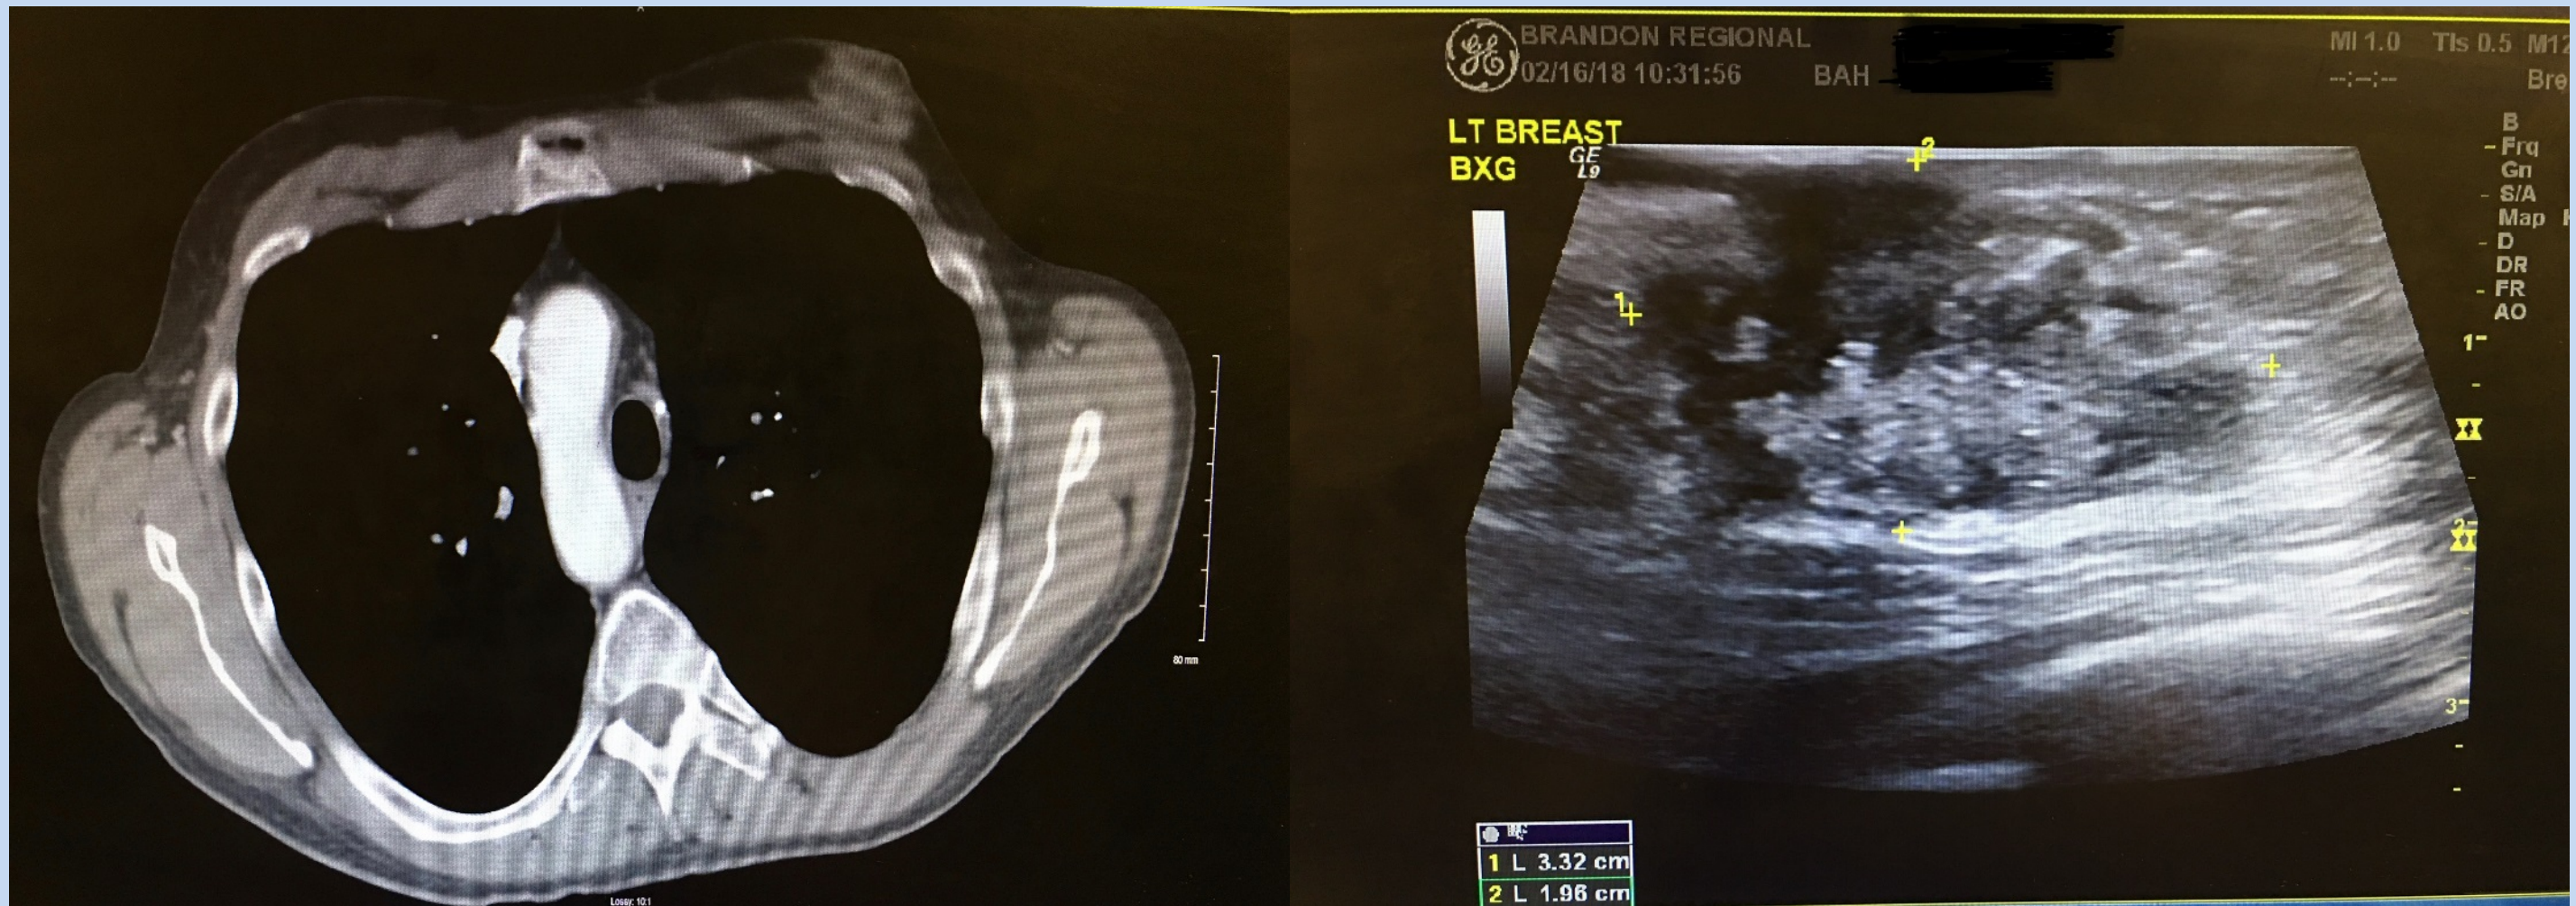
CT Chest with contrast showing left breast cancer
